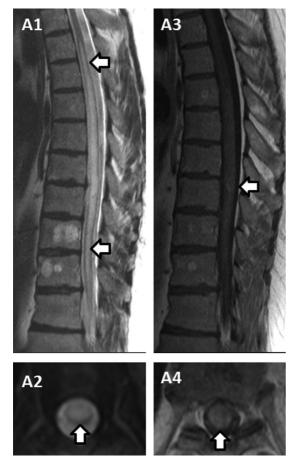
MRI features in spinal dural arteriovenous fistula. Sagittal T2-weighted imaging shows a longitudinally extensive T2-hyperintense lesion spanning the thoracic spinal cord (A1, arrows). Sagittal T1-weighted imaging with gadolinium shows possibly faint contrast enhancement throughout and some vague spots of enhancement (A3, arrow). Axial T2-weighted view shows holocord T2-hyperintense signal on cross-sectional view (A2, arrow) again with some patchy gadolinium enhancement accompanying (A4, arrow).
